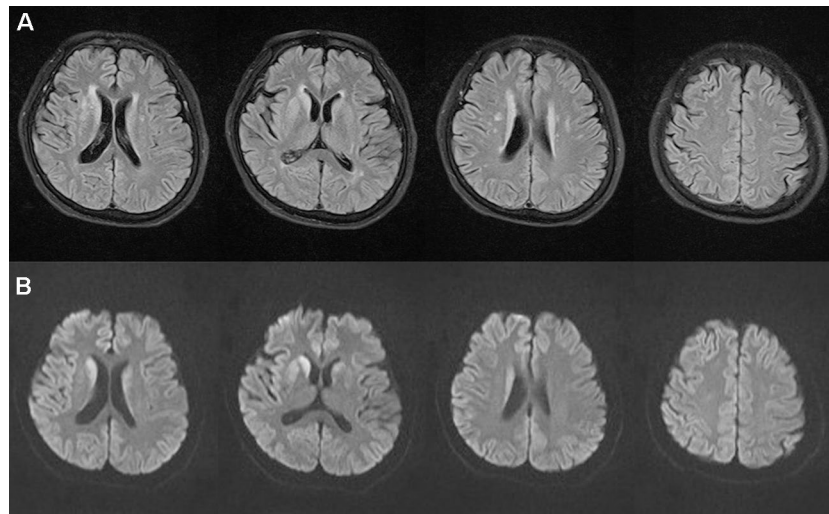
Brain magnetic resonance imaging magnetic. Fluid-attenuated inversion recovery (A) showed hyperintensities in the bilateral frontal lobe, corona radiata, and near the anterior and posterior horns of the lateral ventricle. Diffusion-weighted imaging (B) showed hyperintensities in the bilateral caudate nucleus and putamen on November 1, 2017.
